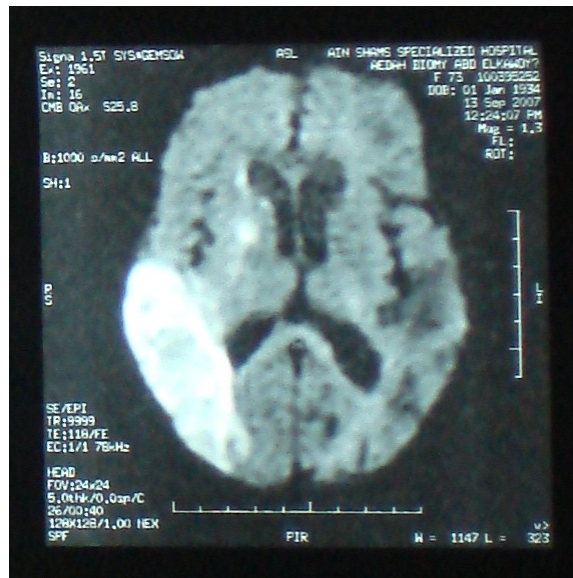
Diffusion-weighted MRI showing partial anterior circulation infarction of the area supplied by posterior branch of MCA in a patient with atrial fibrillation.
